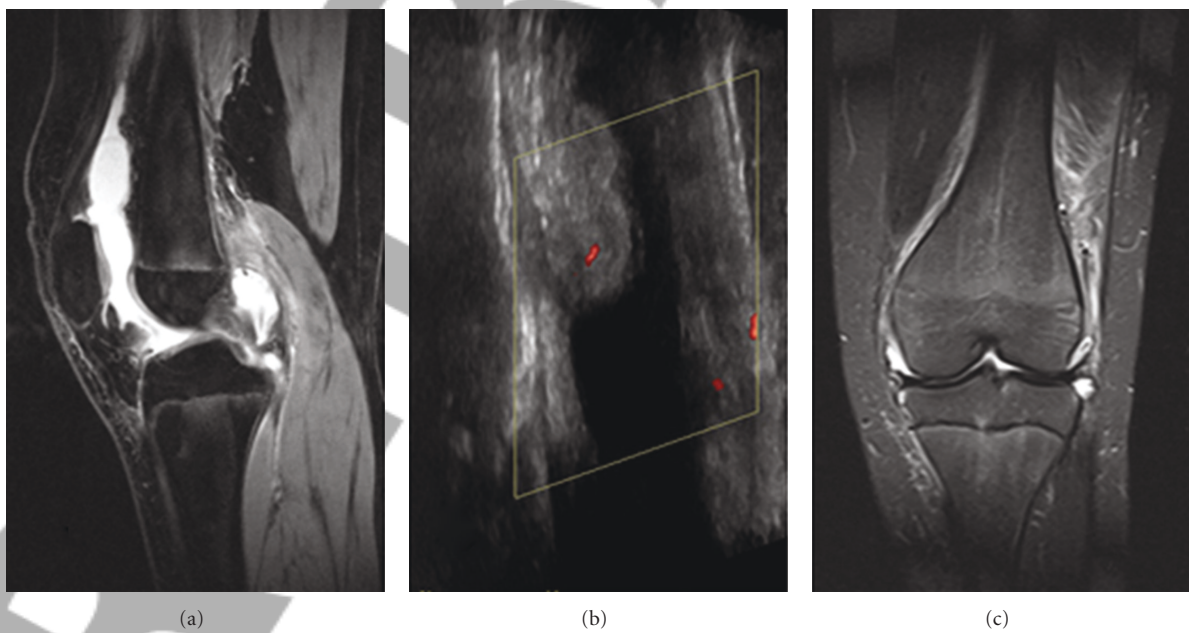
MRI and US of the left knee at the disease presentation. T2-weighted sagittal image (a) and US (b) demonstrated synovial thickening with increased vascularity (b) and joint effusion. The signal intensity of the distal femur and proximal tibia is normal (a), (c).
